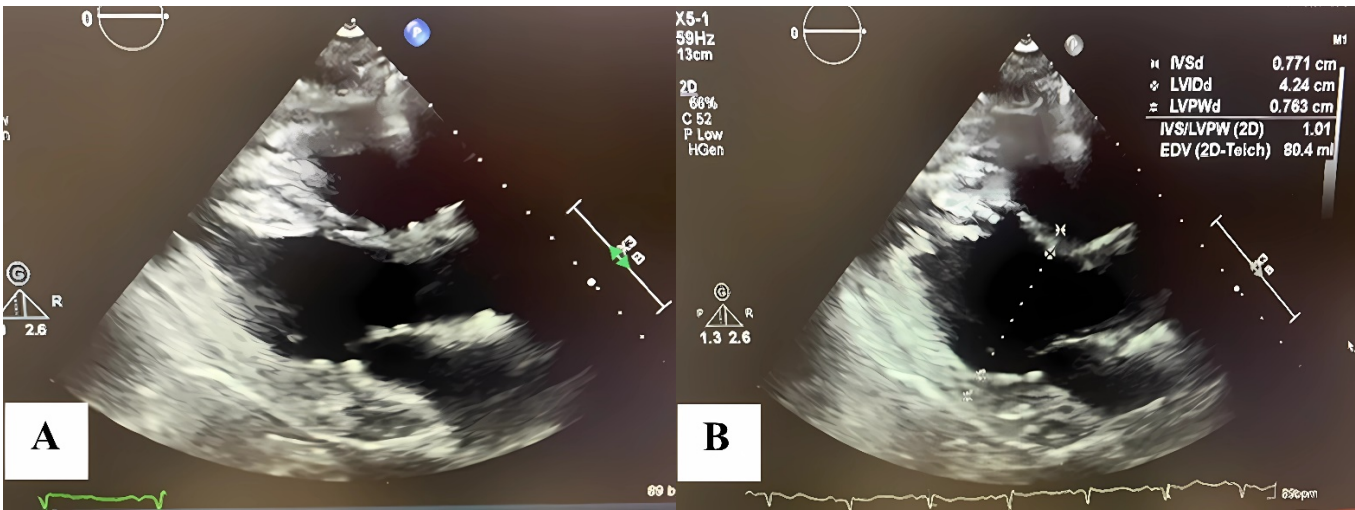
A follow-up transthoracic echocardiogram was performed approximately two months after discharge. (A) Systolic and (B) Diastolic images show complete normalization of left ventricular function, with resolution of apical ballooning and absence of thrombus.
